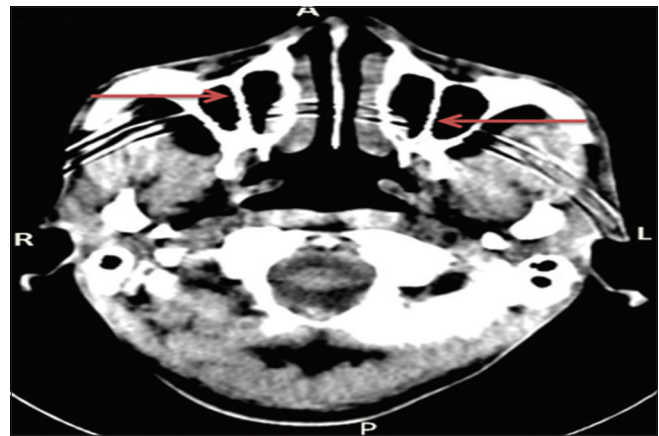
Axial computerized tomography (CT) slide of a 55-year-old male showing bilateral septa (arrows) completely dividing each maxillary sinus anteroposteriorly into two compartments. R = right side, L = left side, A = anterior, P = posterior
